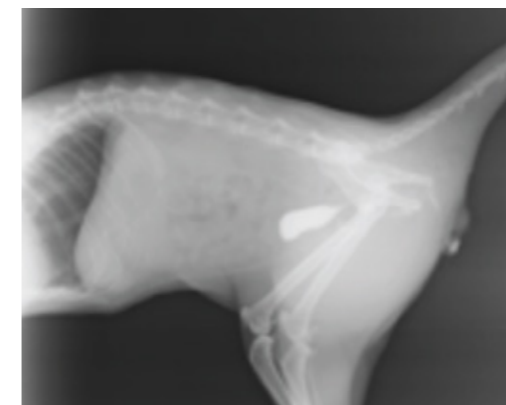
Radiographic findings from contrast cystography examination using iodinated contrast media.
